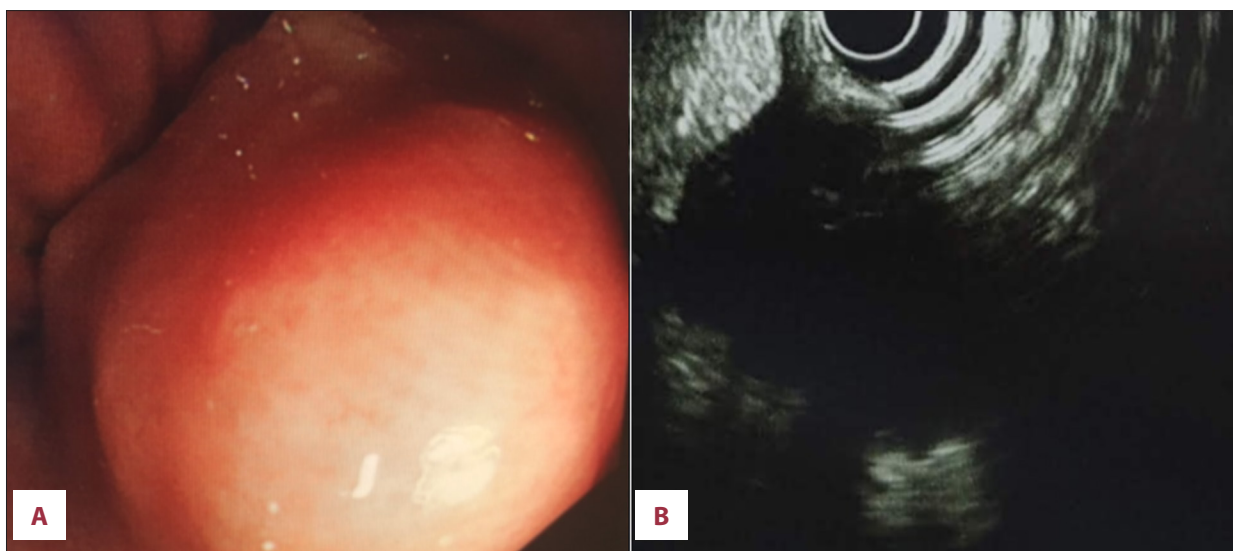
(A) Endoscopic view showing an elevated mass in the gastric antrum with normal overlying mucosa. (B) Endoscopic ultrasound examination showing a hypoechoic, well-demarcated, oval-shaped mass lesion.
